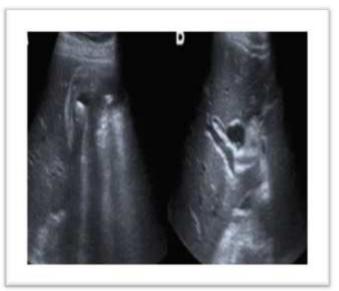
a)Abdominal ultrasound showing gallbladder wall thickening, pericholecystic fluid and cholelithiasis. b) Endoscopic retrograde cholangiopancreatography showing multiple stones in the Fgallbladder.
